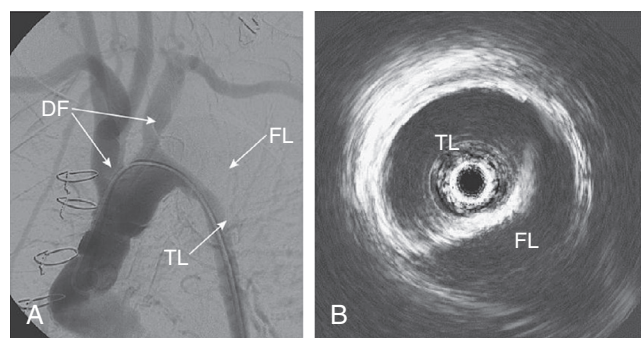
■ (A) Angiogram and (B) intravascular ultrasound image of a patient with type A dissection of the aortic arch. The false lumen (FL) and true lumen (TL) are evident in the intravascular ultrasound image. The arrows on the angiogram correlate with the site of the intravascular ultrasound image. DF, Dissection flap.
